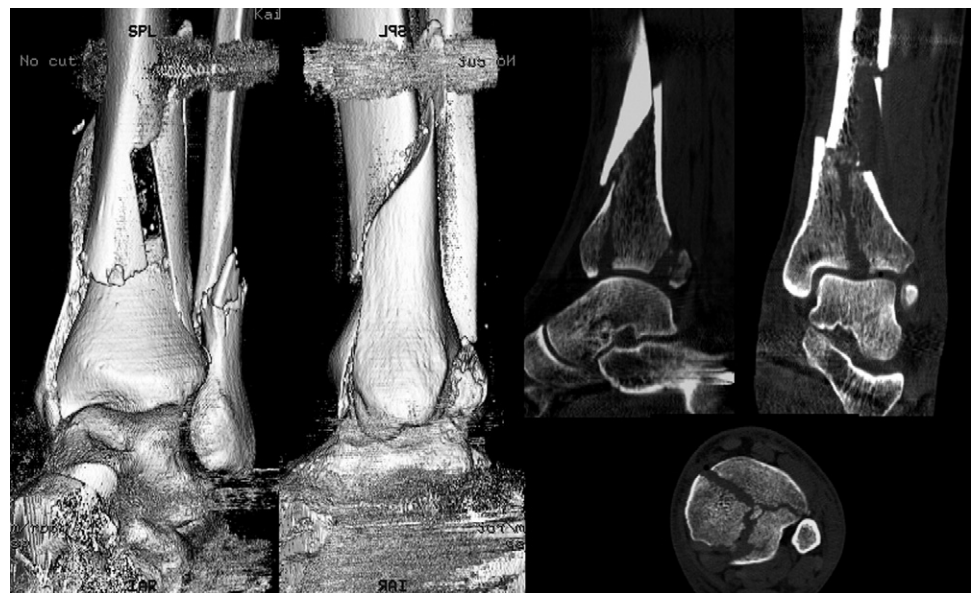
Same patient as [Figure 5](#). CT (with 3D reconstruction) following temporary external fixation allows for planning of hardware placement. Tibial plafond has 3 major fragments.
